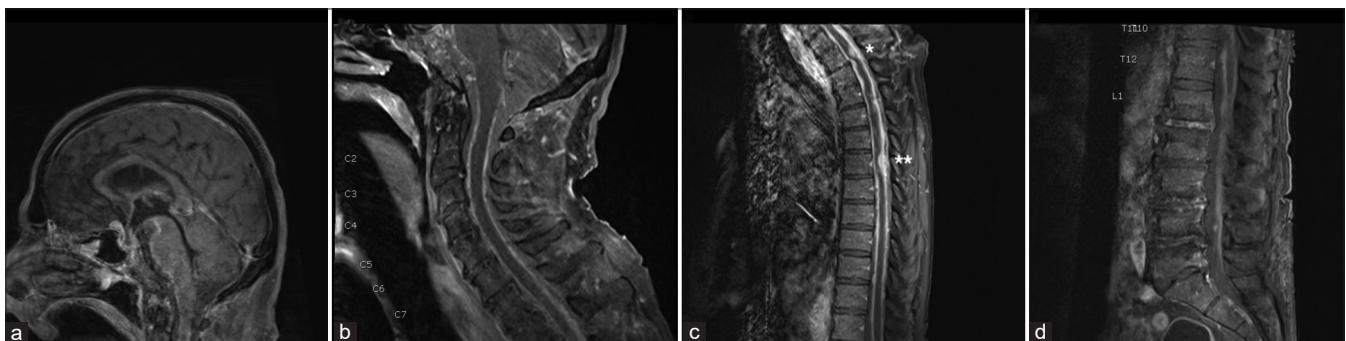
Magnetic resonance imaging T1 sequences with gadolinium contrast- parasagittal views. (a) Brain - Suprasellar enhancement, leptomeningeal enhancement seen along the ventral brainstem and pineal region. (b) Cervical spine- Diffuse leptomeningeal enhancement seen in the ventral/dorsal spinal cord. (c) Thoracic spine - Dorsally compressive thickened lesions at T1 (single asterick) and T6 (double asterick). (d) Lumbar spine - Diffuse enhancement of the conus medullaris and the cauda equina.
